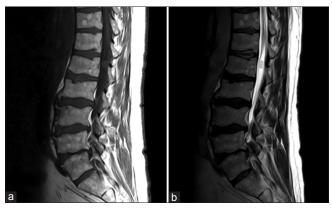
MR imaging revealing a non-enhancing cystic-appearing lesion growing off the conus medullaris at L1-L2 in the spinal with hyperintensity on a sagittalT1-weighted image (a) and hypointensity on a T2-weighted image (b)
